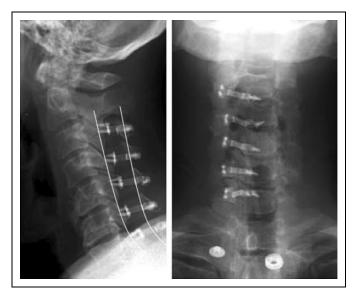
Postoperative cervical radiographs showing bilateral C4-5 foraminotomy.
